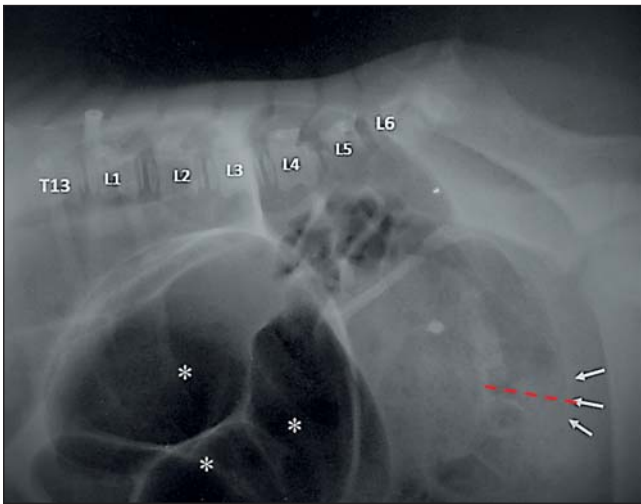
Right lateral pelvic radiograph of a one-day-old buffalo calf demonstrating the absence of sacral as well as coccygeal vertebrae. Note generalized bowel distension with gases (asterisks) and distension of the rectum (dashed line) with presence ampulla of the rectum (white arrows) directed towards the perineal region.
